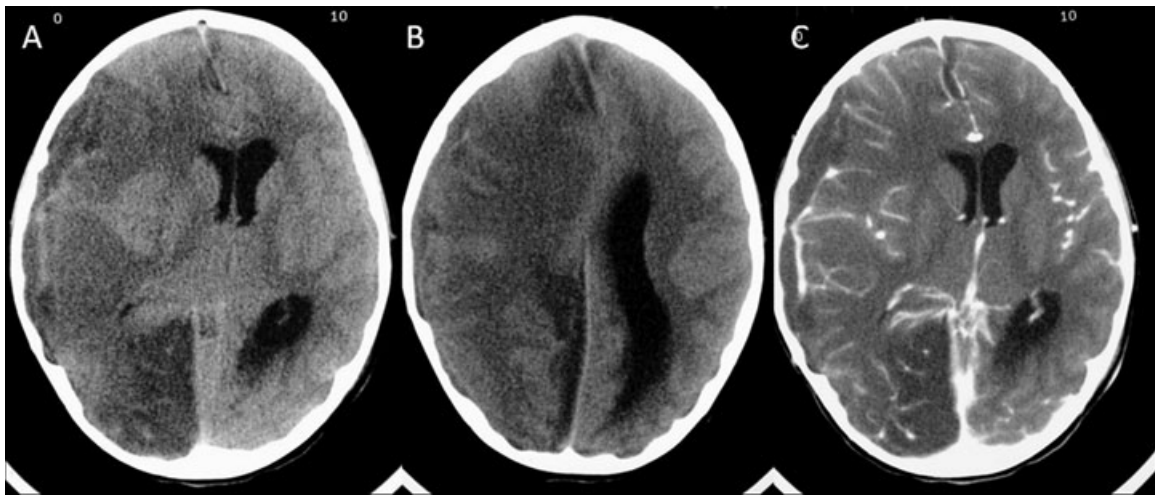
Precontrast (A, B) and postcontrast (C) enhanced axial CT images in a child with severe meningoencephalitis and right sided subdural empyema after previous skull base fracture. In addition, a significant cortical and subcortical edema is seen because of the meningoencephalitis. A significant midline shift is noted with subfalcine herniation of the right lateral ventricle and obstruction of the left lateral ventricle. Focal ischemia in the right occipital lobe resulted from compression of the right posterior cerebral artery.
